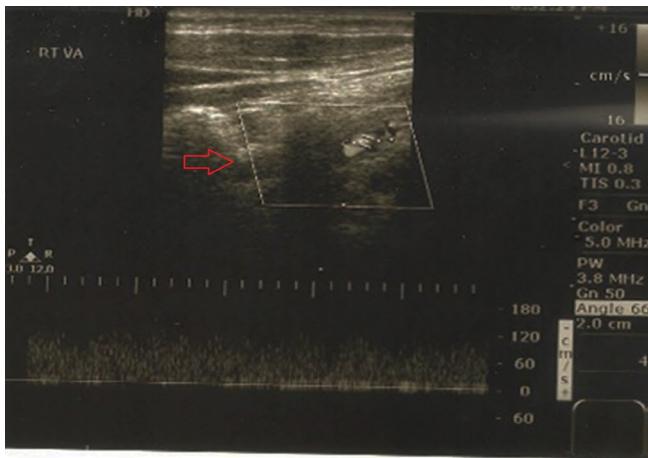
(below) Depicts the Duplex ultrasound scan of the right vertebral artery and the external carotid artery. Both showing a reduced lumen diameter.
